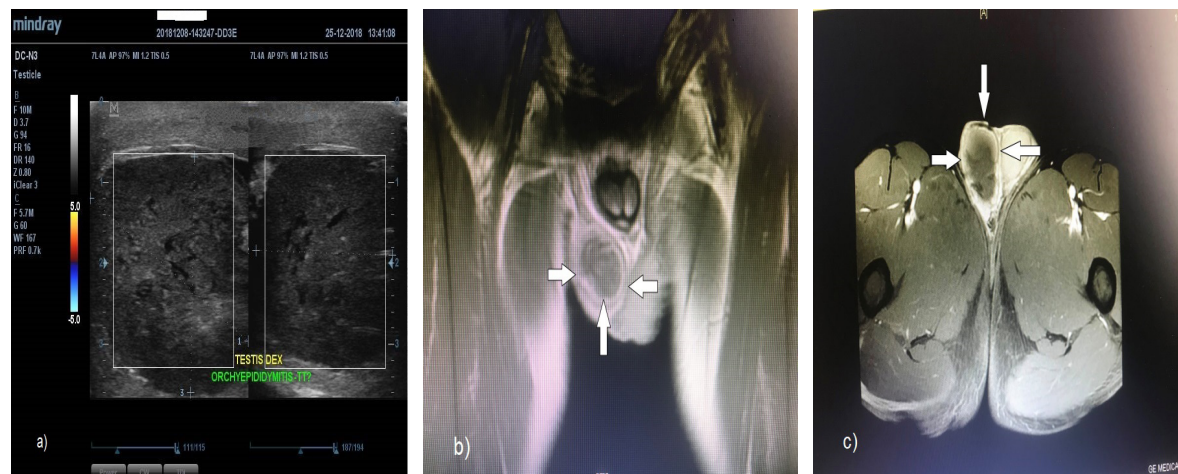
a) Power Doppler of the right testis demonstrates absence of complete blood flow in the right testis; b) and c) CT of the testicles
